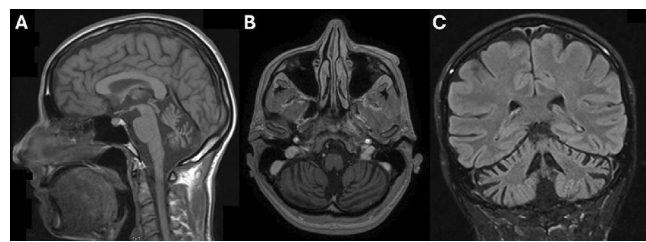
Brain MRI of the proband at 46years old demonstrating cerebellum atrophy on T1-weighted sagittal (A) and axial (B), and T2-weighted coronal (C) sequences.
